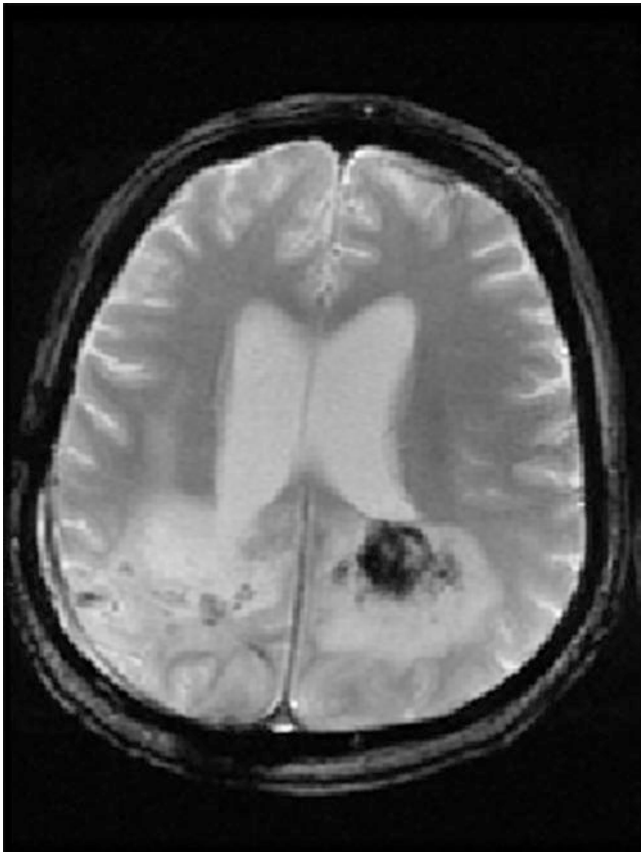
Intratumoral hemorrhage in glioblastoma. Axial T2* MRI of the brain of a 49-year-old man presenting with a 7-day history of confusion. Fluent (Wernicke-type) aphasia on exam. No headaches
